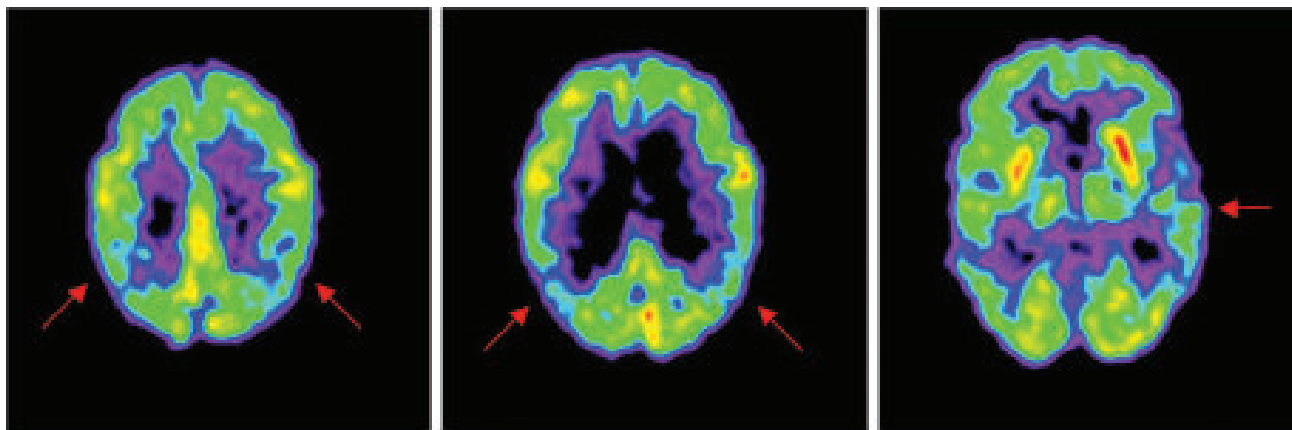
8F-FDG PET images of early AD. Early Alzheimer’s typically affects the parietal, temporal, and posterior cingulate cortices. Brain images of this 80-y-old woman demonstrate hypometabolism of the parietal cortex, bilaterally (left and middle), with relative sparing of the primary visual cortex, sensorimotor cortex, thalamus, and basal ganglia. In the early stages of AD, deficits often appear asymmetrically, as evidenced here by mild hypometabolism of the left temporal cortex (right). In later stages of the disease, degeneration will be apparent bilaterally.
